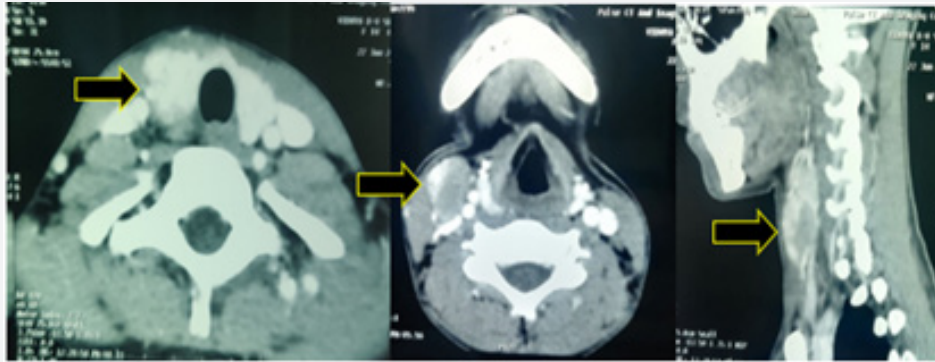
CT scan (axial and sagittal view) showing right side level II lymph node enlargement with microcalcification and loss of fatty hilum.
